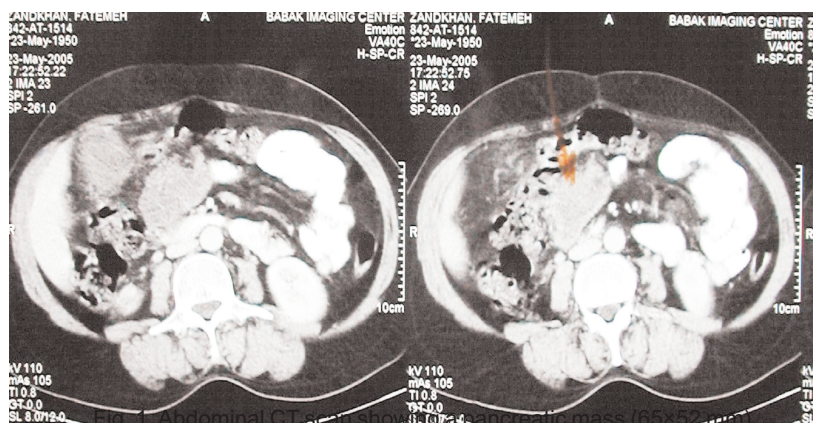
Abdominal CT scan showing a pancreatic mass (65×52 mm)
